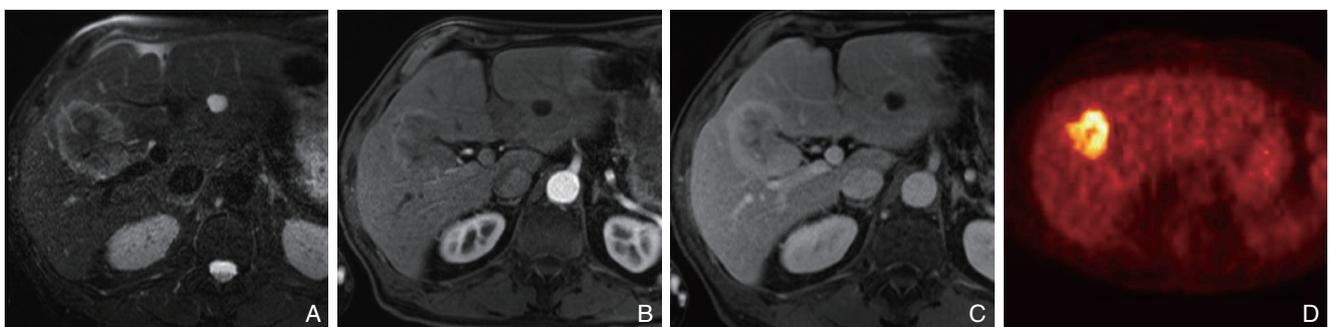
A 为 T₂ 像; B 为肝动脉期对比增强; C 为门静脉期; 在 T₂ 像中肿块呈轻微增强, 而在肝动脉期肿块边缘强化, 在门静脉期表现为中央部的坏死; D 为 FDG PET 显示中央部的坏死
